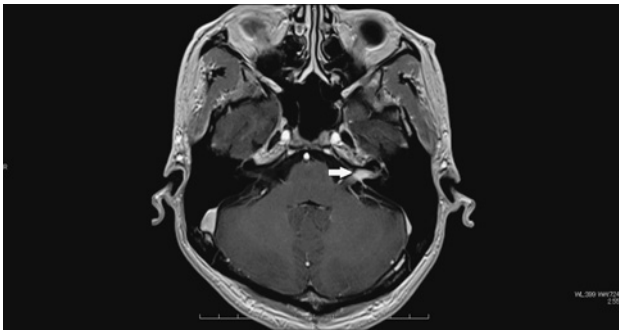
Head MRI showed a high-intensity area (arrow) from the left cerebellopontine angle to the internal acoustic meatus. Ramsay Hunt syndrome was suspected from this finding.
